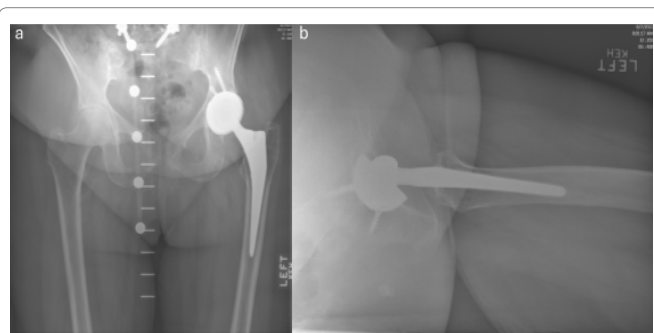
Case 3: Post-revision anteroposterior (a) and lateral (b) radiographs with no signs of impingement.
